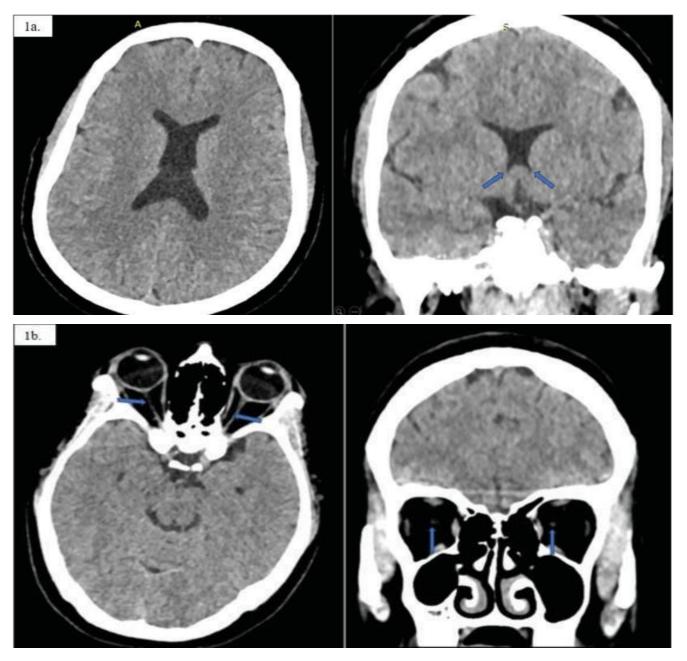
1a. Axial and coronal CT images showing the absence of the septum pellucidum with the inferior pointing of the frontal horns of the lateral ventricle in the coronal view (blue arrows). 1b. Axial and coronal CT scan images demonstrating hypoplastic bilateral optic nerves (blue arrows)
